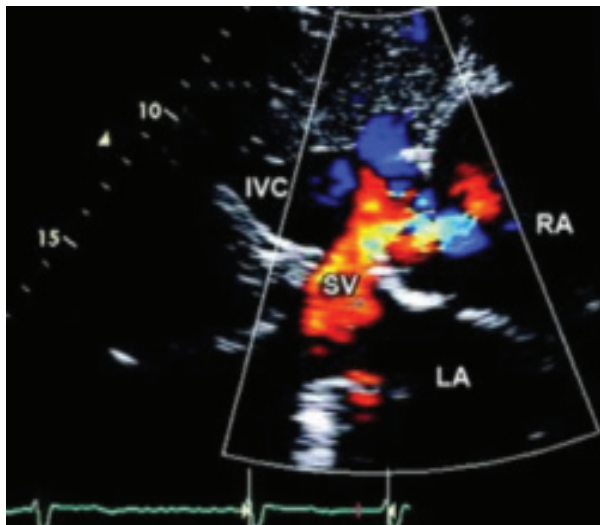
subcostal echocardiography showing modified bicaval view with drainage of scimitar vein into IVC (SV= Scimitar vein, IVC=Inferior vena cava, RA= Right atrium, LA= Left atrium)
